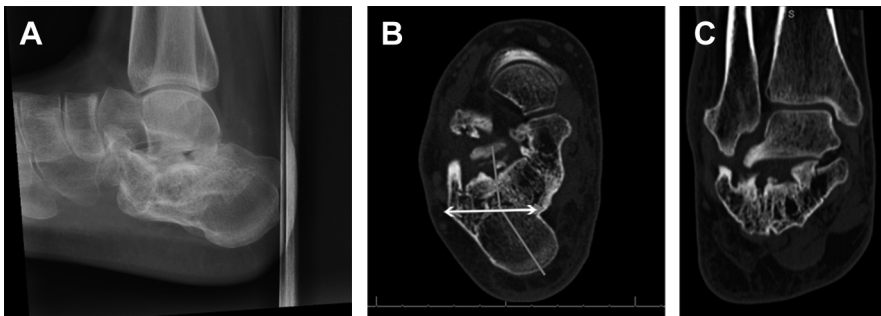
(A) Lateral weight-bearing radiograph of a 23-year-old woman shows a calcaneal malunion with loss of height and Böhler's angle. Also, note the subsidence of the talus into the calcaneus creating anterior ankle impingement. (B) Axial view of the CT scan shows expansion of the lateral wall (arrow) and the severe varus angulation of the posterior tuberosity with shortening. (C) Semicoronal view of the CT scan shows subfibular impingement and subtalar arthrosis. Note the presence of the healed distal fibular avulsion fracture from injury to the superior peroneals retinaculum suggestive of chronic peroneal dislocation.
